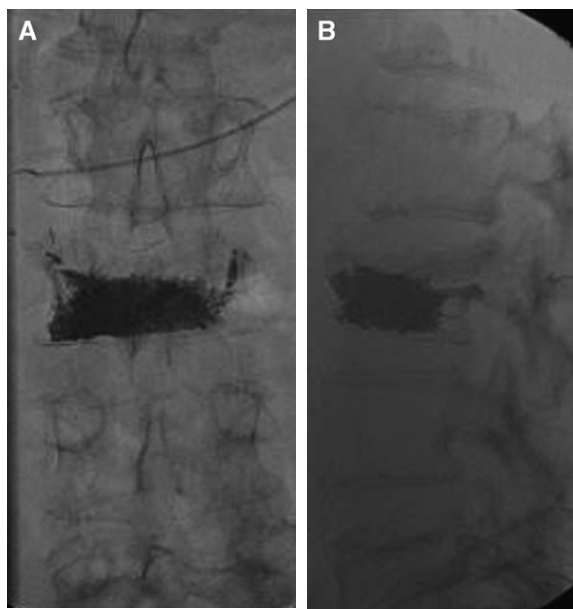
Frontal (*A*) and lateral (*B*) radiographs after injection of polymethylmethacrylate cement mixed with barium. Ideally, the cement permeates the anterior three quarters of the vertebral body and at least two thirds of its transverse dimension.
